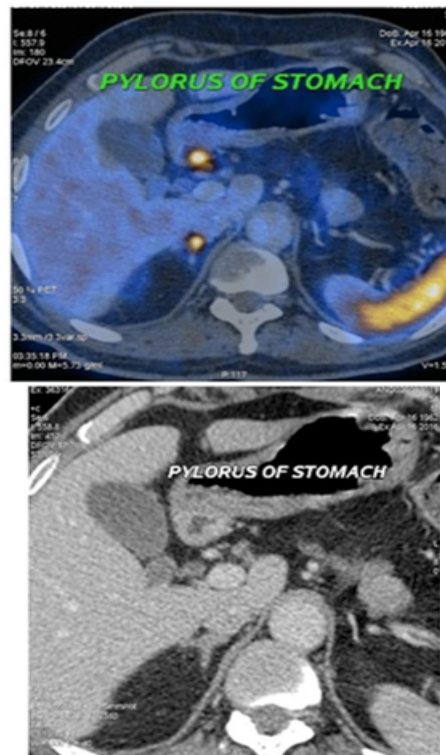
Comparison of metastasis in the pylorus of the stomach between DOTANOC and CT scan.
